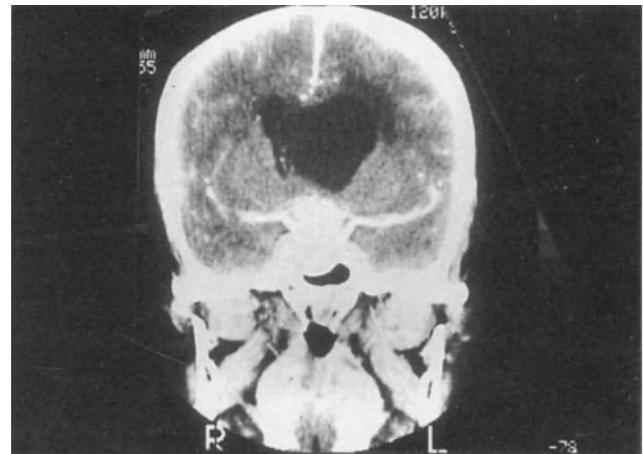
CT scan coronal view of an expansive macroadenoma leading to intracranial hypertension (note the dilated lateral ventricles).
